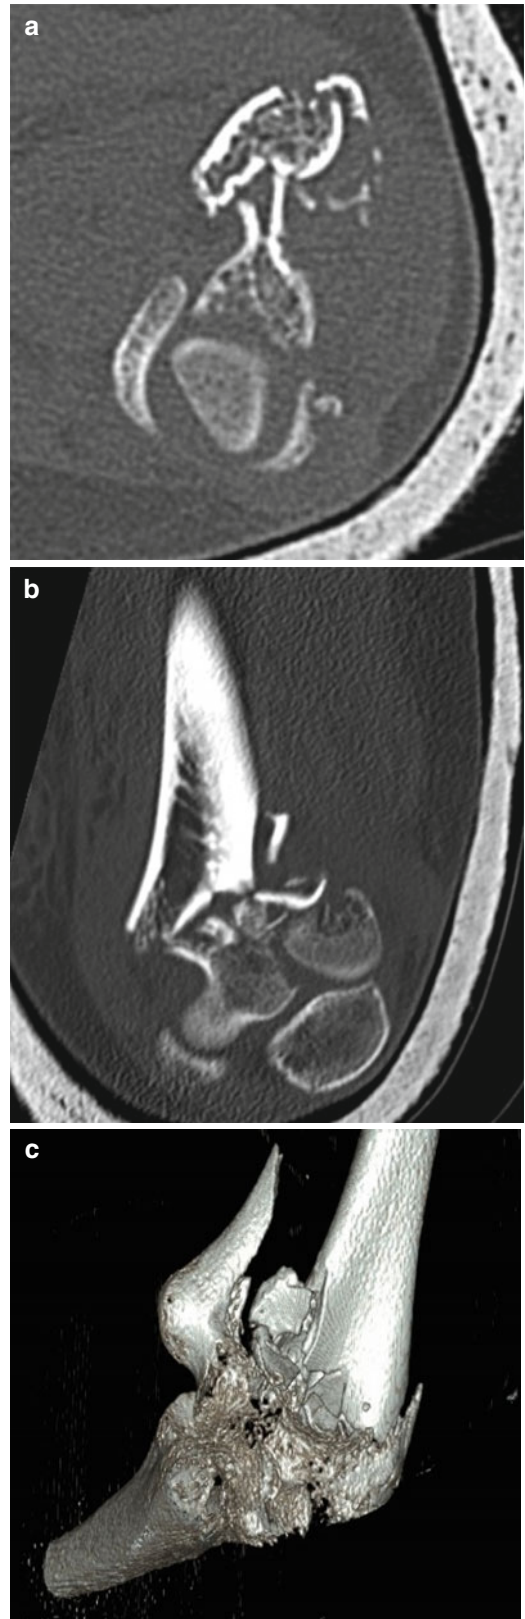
Accurate preoperative planning is mandatory to successfully treat comminuted fractures of the distal humerus: 2D and 3D reconstructions should be obtained in all the cases. (a, b) preoperative x-rays, showing displaced distal humeral fracture with comminution of the articular surface. (c) postoperative x-rays showing anatomical reduction and plate fixation
